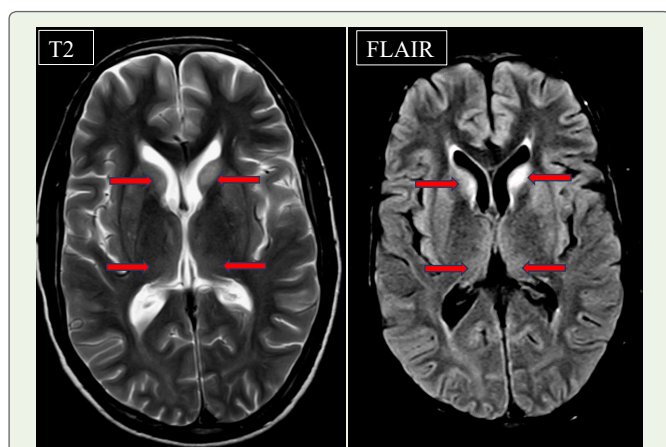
T2W and FLAIR axial section of MRI brain shows hyperintensities in head of bilateral caudate nucleus. Also seen is hyperintensity in thalami (more evident on FLAIR).
